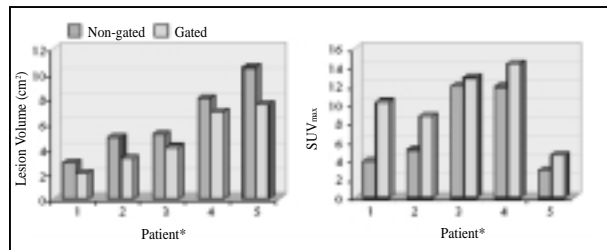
Gated PET effects: Lesion volume and SUVmax. Reproduced with permission from the source.
